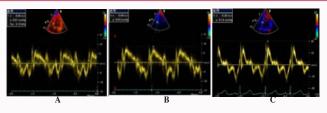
Tissuedoppler derived velocity shows incremental increase in velocity of S wave from 7m/sec at resting (A) To 14m/sec at low dose; (B) To 20 m/sec at peak dose (c)
